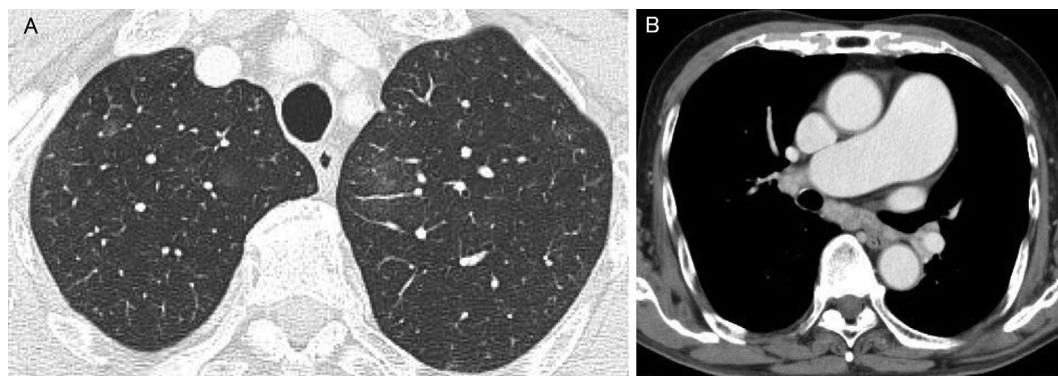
(A) Chest high-resolution computed tomography (CT) showed diffuse micronodules and ground-glass opacity in the centrilobular lung fields. (B) Contrast CT showed an enlarged pulmonary artery and mediastinal lymphadenopathy.
